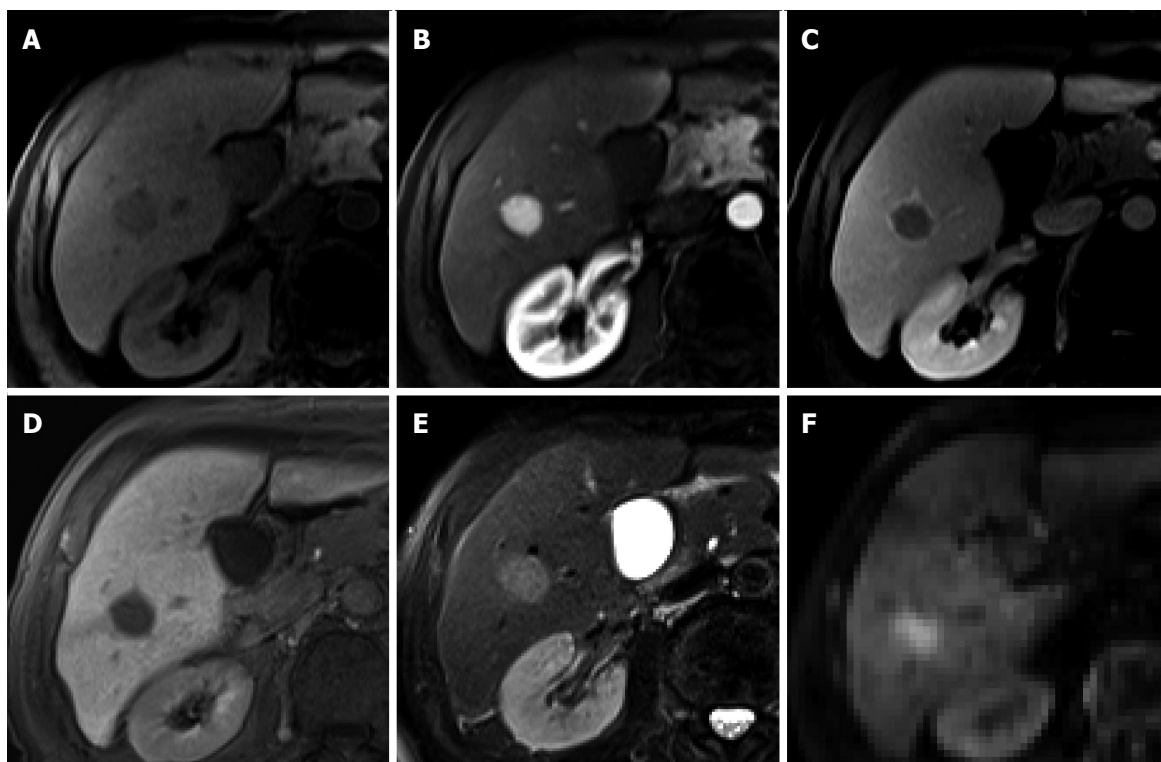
Hepatocellular carcinoma in a 74-year-old man with hepatitis C infection. A: Precontrast T1-weighted image shows a hypointense nodule in segment 6; B: Hepatic arterial phase of gadoxetic acid-enhanced MRI shows homogeneous marked enhancement of the tumor; C: Transitional phase shows washout of the contrast medium in the tumor with capsular enhancement; D: Hepatobiliary phase shows marked hypointensity of the tumor relative to the liver parenchyma; E, F: T2-weighted image and diffusion weighted image ($b = 800$) show high SI of the tumor.
